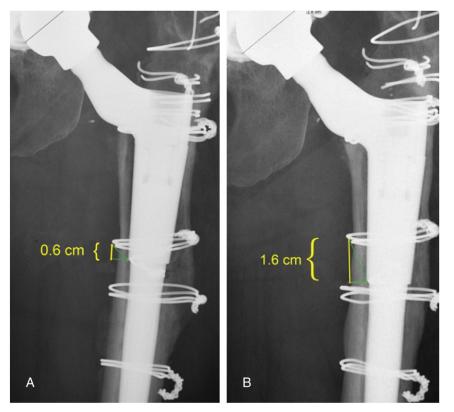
(A) Immediate postoperative radiograph; (B) same patient one year later showing stem subsidence of 1 cm.
